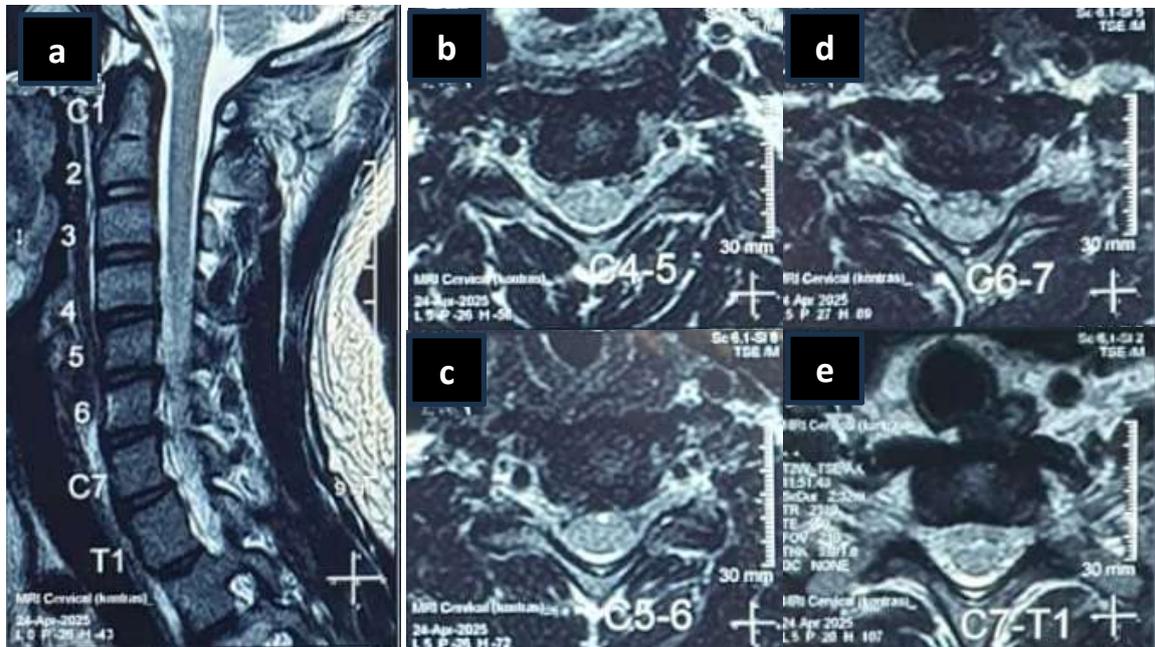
Magnetic Resonance Imaging (MRI) of the cervical spine.
